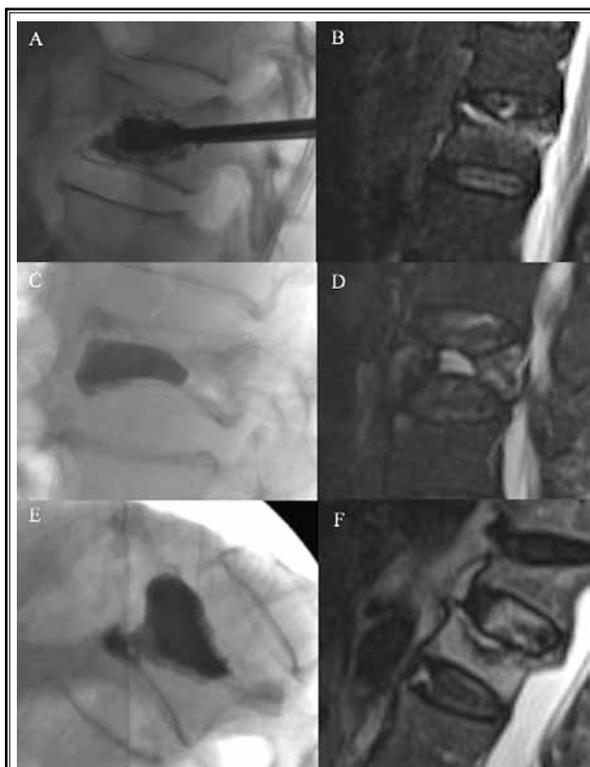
Cement fill patterns during fluoroscopy, with MR images of the corresponding cleft. Vertebral body only cement pattern (A and B), cleft-only cement fill pattern (C and D), and combined vertebral body and cleft cement fill pattern (E and F).
